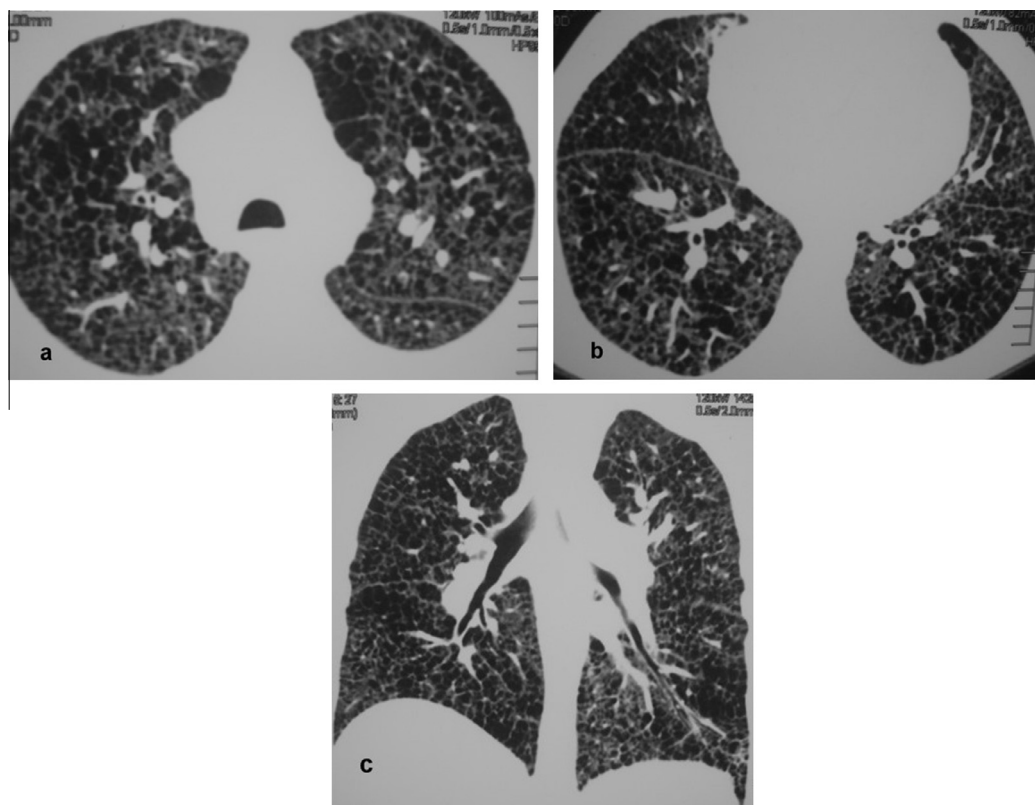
(a–c): 40-year-old female patient with LAM presenting with dyspnea and dry cough. HRCT axial (a, b) and coronal (c) images show numerous bilateral air-filled cysts evenly distributed in the lung lobes with thickened fissures. All cysts are less than 1.5 cm in diameter.
